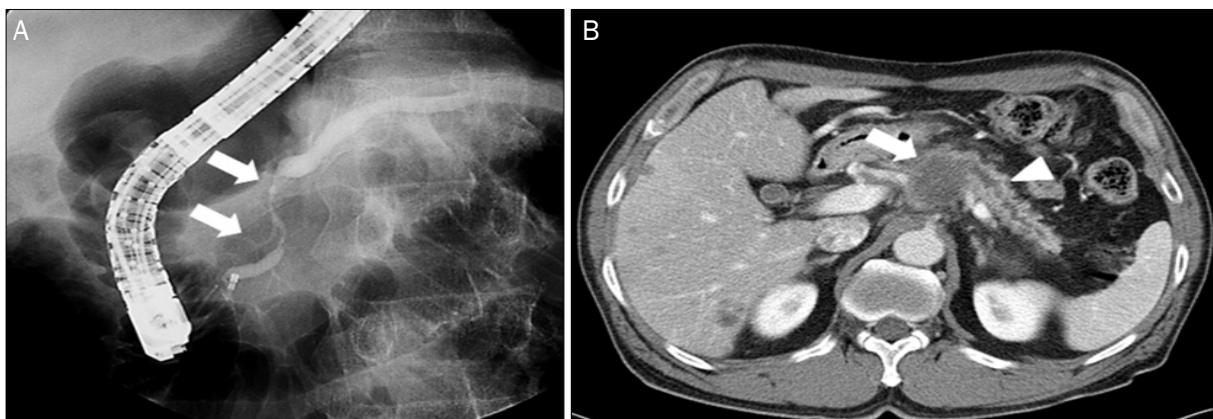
Unusual cause of acute pancreatitis-pancreatic cancer. (A) Fluoroscopic image taken during ERCP shows focal segmental pancreatic duct narrowing (double arrows) in the proximal body area with post-stenotic dilatation. (B) About 3.0 cm sized ill-defined mass (arrow) of the proximal body of pancreas and pancreatic duct dilatation (arrowhead) of the tail is observed in CT axial view. ERCP, endoscopic retrograde cholangiopancreatography; CT, computed tomography.
